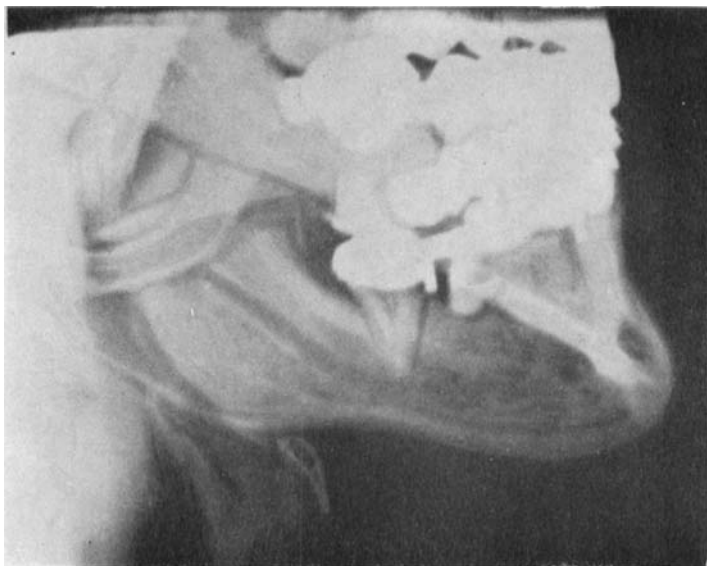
Same case as no. 9. X-ray check-up done January 25, 1950. There is further forward and upward displacement of the upper fragment, which has been dislocated by 90°. With good contact between the fragments this forward displacement had not been possible.
